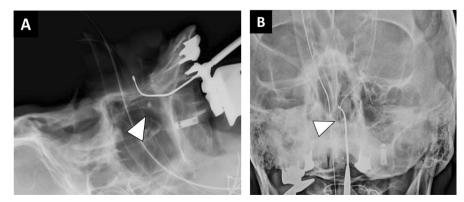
Intraoperative plain radiograph. (A) frontal view. (B) lateral view. The foreign object was damaged due to corrosion, and its remnants were confirmed on the intraoperative radiograph. The insertion of an instrument clarified the position of the residual foreign body (arrow). The presence of residual foreign body at the arrow-indicated site led to its removal after imaging.
